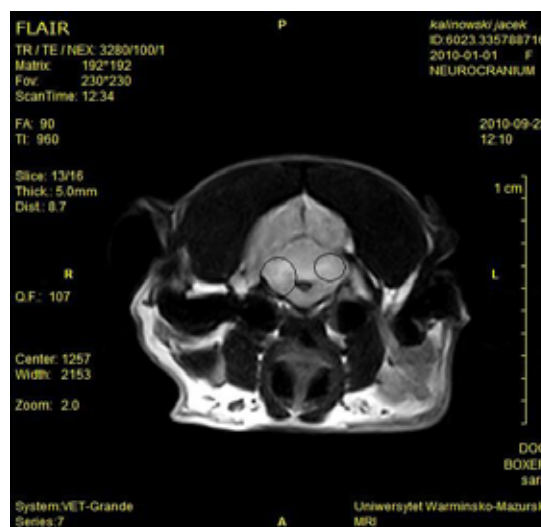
FLAIR image, in transverse plane. Hyperintense lesions in the pons region.
